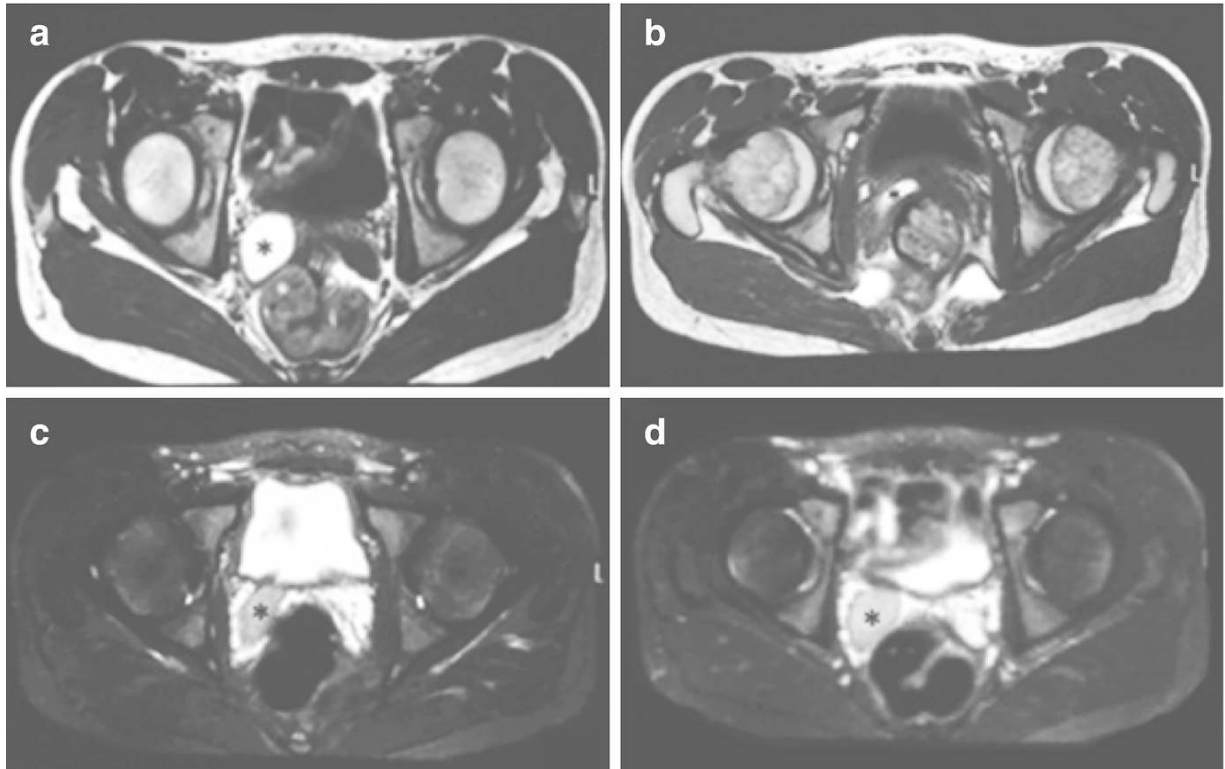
MRI demonstrating large SV cyst
